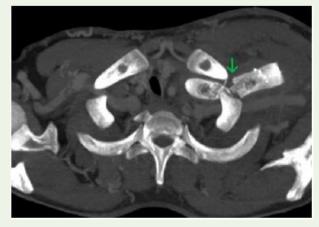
Computed tomography venography of thorax axial reformatted maximum intensity projection mediastinal window image shows broken stents in the left subclavian vein.
